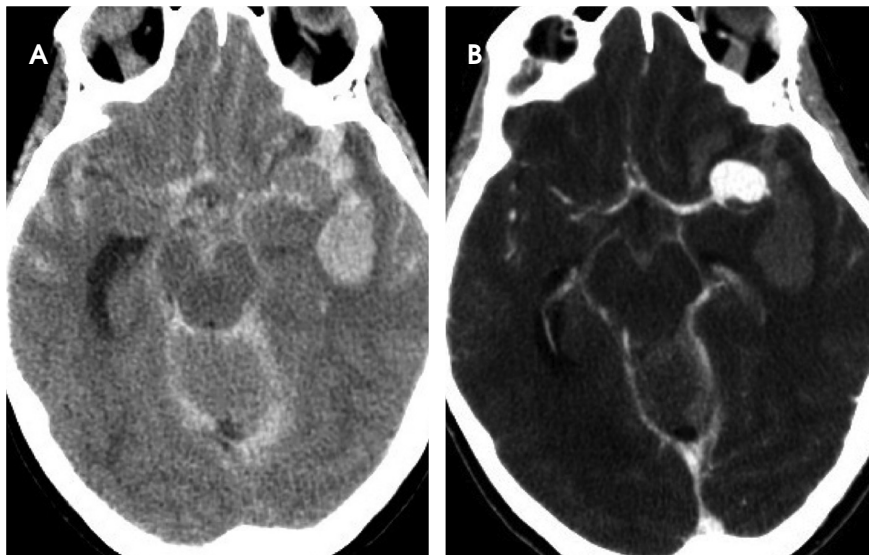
(A) Noncontrast CT demonstrating diffuse SAH, most pronounced in the left MCA cistern. (B) Left MCA aneurysm seen on CTA.
